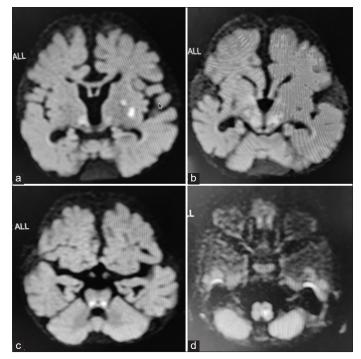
(a-d) DWI images showing areas of restricted diffusion in basal ganglia, thalami, and brain stem
